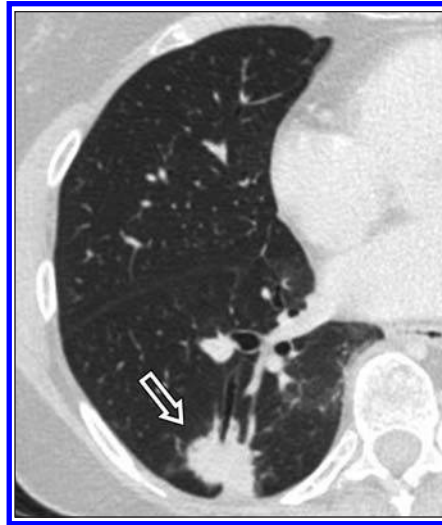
Bronchocentric granulomatosis. Transverse CT image of chest shows unilateral solitary mass (arrow) in right lung with nonspecific appearance.
